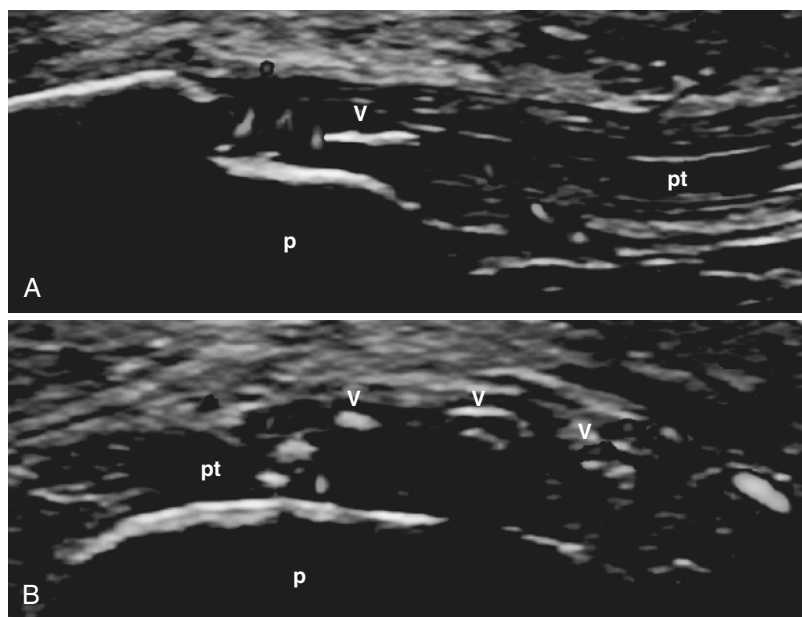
CHRONIC GOUT. Longitudinal (A) and transverse (B) views of the proximal insertion of the patellar tendon show tophaceous deposits (arrowheads) surrounded by evident power Doppler signal. p, patella; pt, patellar tendon.
